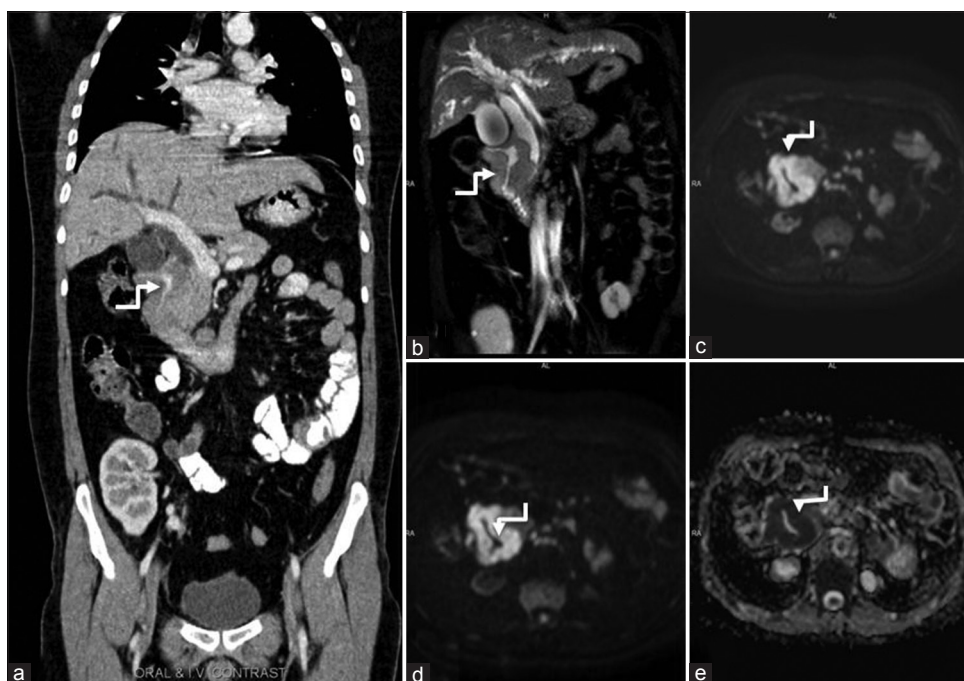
(a) Contrast enhanced computed tomography abdomen coronal reformat showing circumferential infiltrative nodular hypodense mural thickening involving second part of duodenum (arrow) with mild upstream dilatation of intrahepatic biliary radicals and common bile duct. (b) Coronal T2-weighted image showing mild T2 hyperintense duodenal mural thickening (arrow) with marked diffusion restriction on diffusion weighted imaging (c and d) and hypointensity on corresponding ADC images (e)
